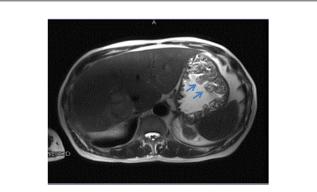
Magnetic resonance imaging showing multiple gastric polypoid masses (arrows).
